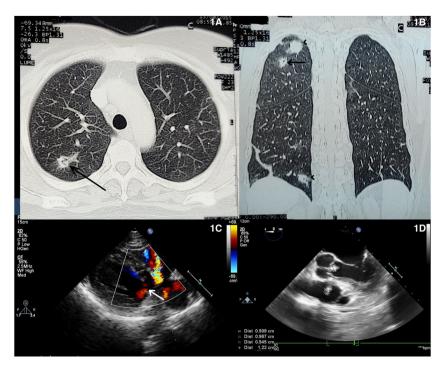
(A and B) Contrast enhanced computed tomography of chest showed multiple irregular nodules in both lung with central cavitation and surrounding consolidation. (C and D) Transthoracic echocardiography showing ventricular septal defect with two vegetations on non-coronary cusp and right side of interventricular septum.
